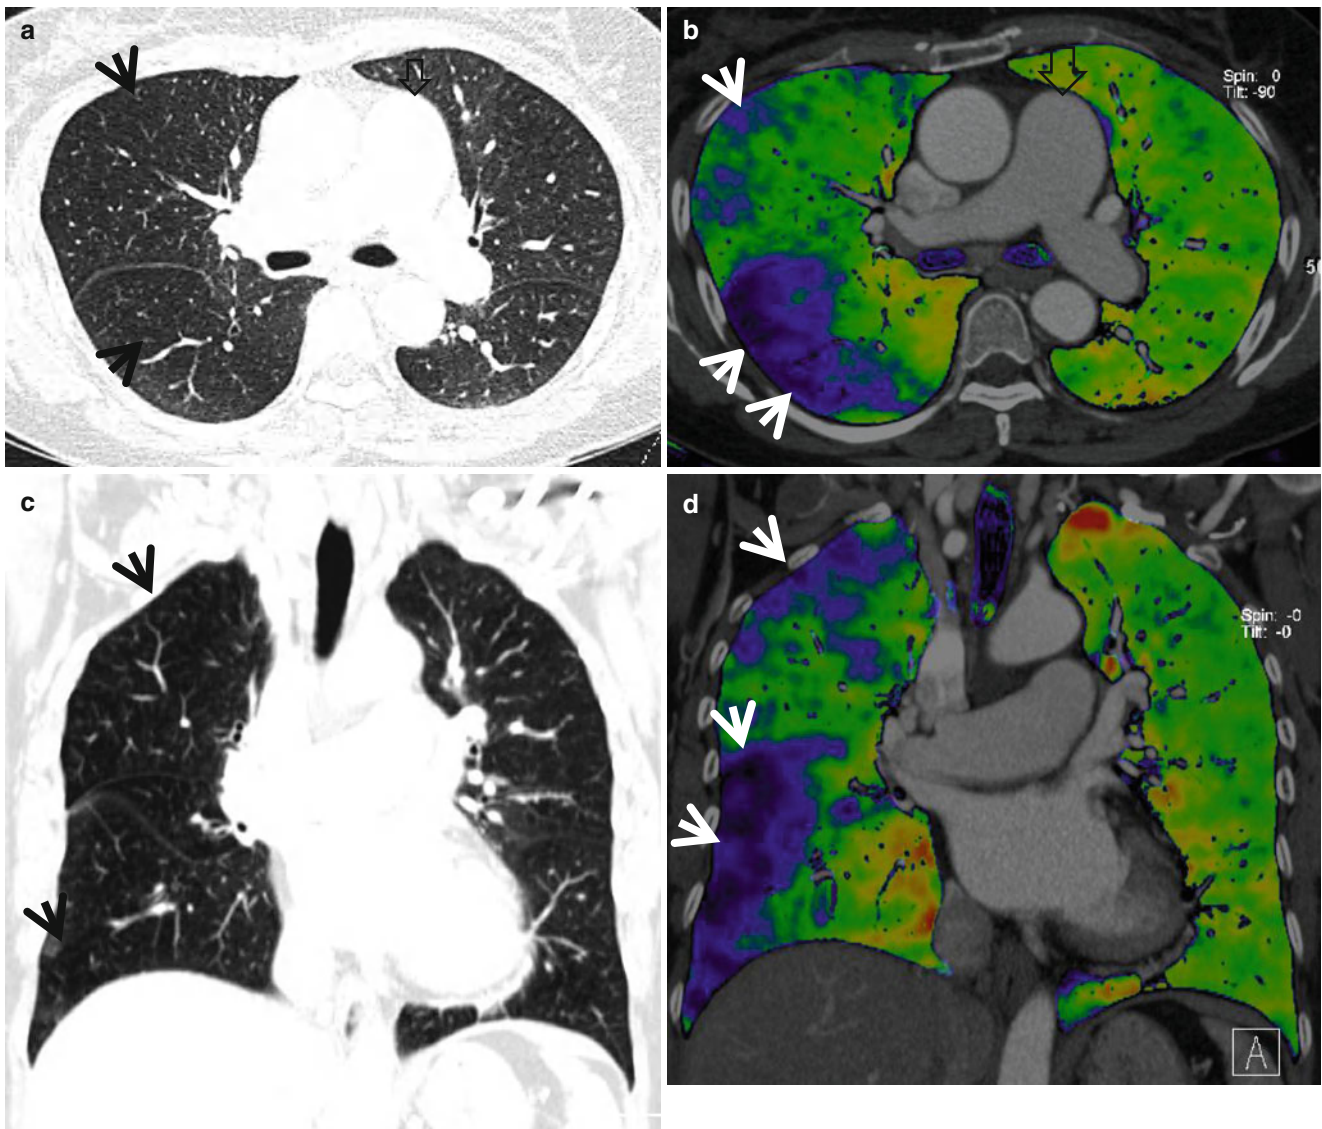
Mosaic perfusion in a 58-year-old woman with chronic thromboembolism and pulmonary arterial hypertension. (a) Lung window image of CT scan (1.0-mm section thickness) obtained at level of main bronchi shows mosaic attenuation areas (arrows) in right lung. Also note markedly enlarged main pulmonary artery. (b) Iodine
